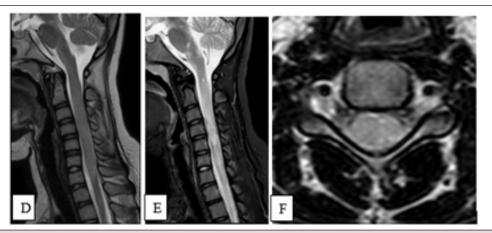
MRI Spine (2021) showed longitudinally extensive transverse myelitis (Case 1).
